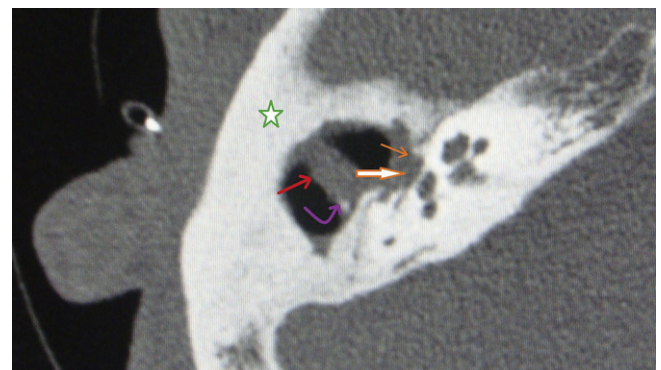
High resolution computed tomography (HRCT) of the temporal bone (axial section at the level of the superior portion of the cochlea and vestibule). The temporal bone shows sclerotic changes (green star) with fat density lesion (red arrow) in the middle ear cavity. A remnant of the ossicular chain is visualized (purple curved arrow). In this image, the lateral wall of the horizontal segment of the facial canal is eroded (orange arrows).
